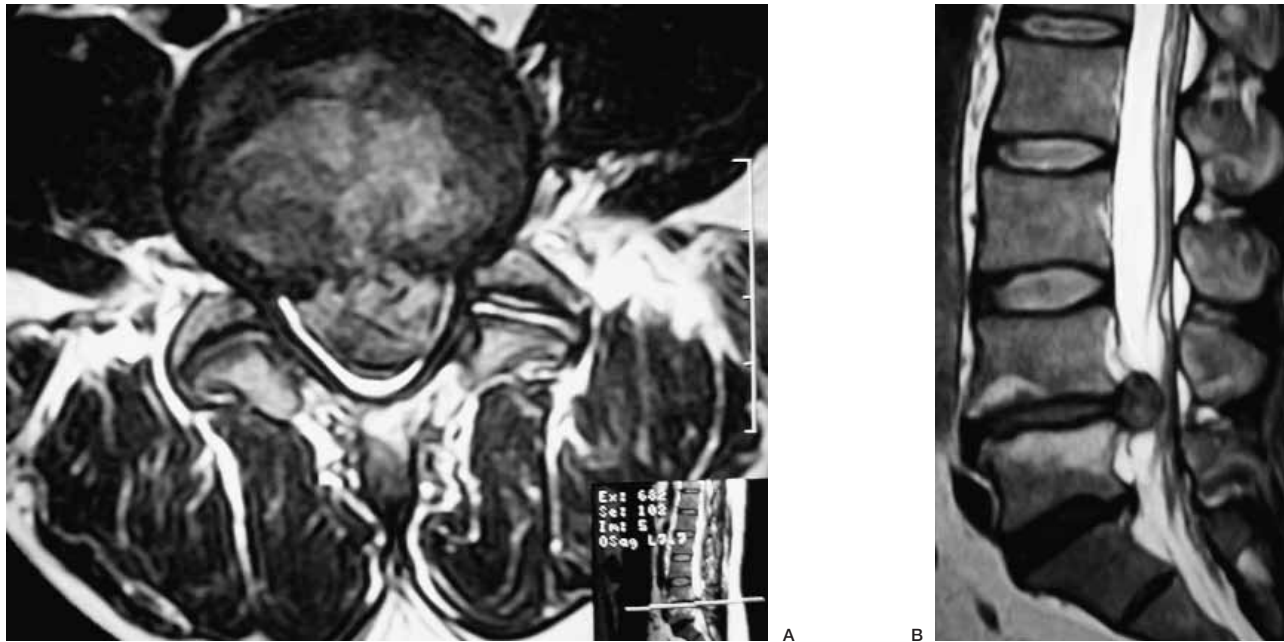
T2 weighted MRI image demonstrating a massive L4-5 disc prolapse nearly occupying the entire canal.
